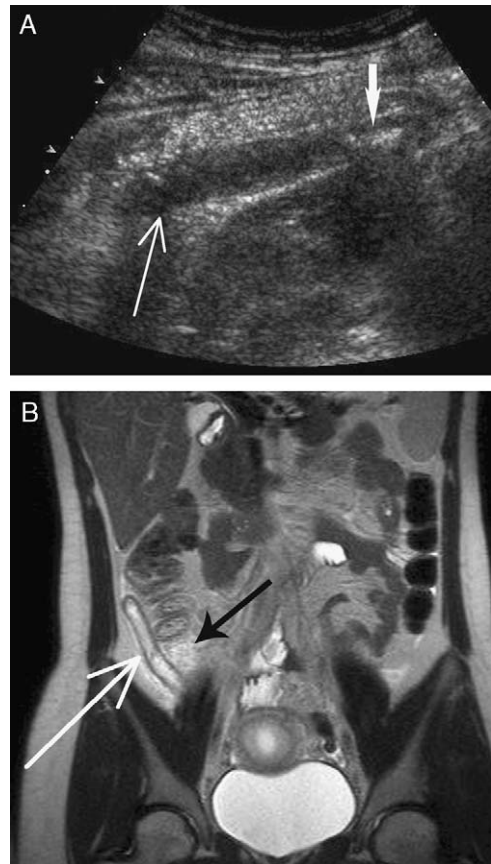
Acute appendicitis in a pregnant patient. (A) Ultrasound shows a blind-ending, tubular structure (long arrow) measuring greater than 6 mm in diameter. A shadowing appendicolith (short arrow) is also seen. (B) Coronal T2-weighted magnetic resonance imaging better demonstrates the dilated, fluid-filled bright appendix (white arrow). The periappendiceal fat is also hyperintense (black arrow) from edema and inflammation.
